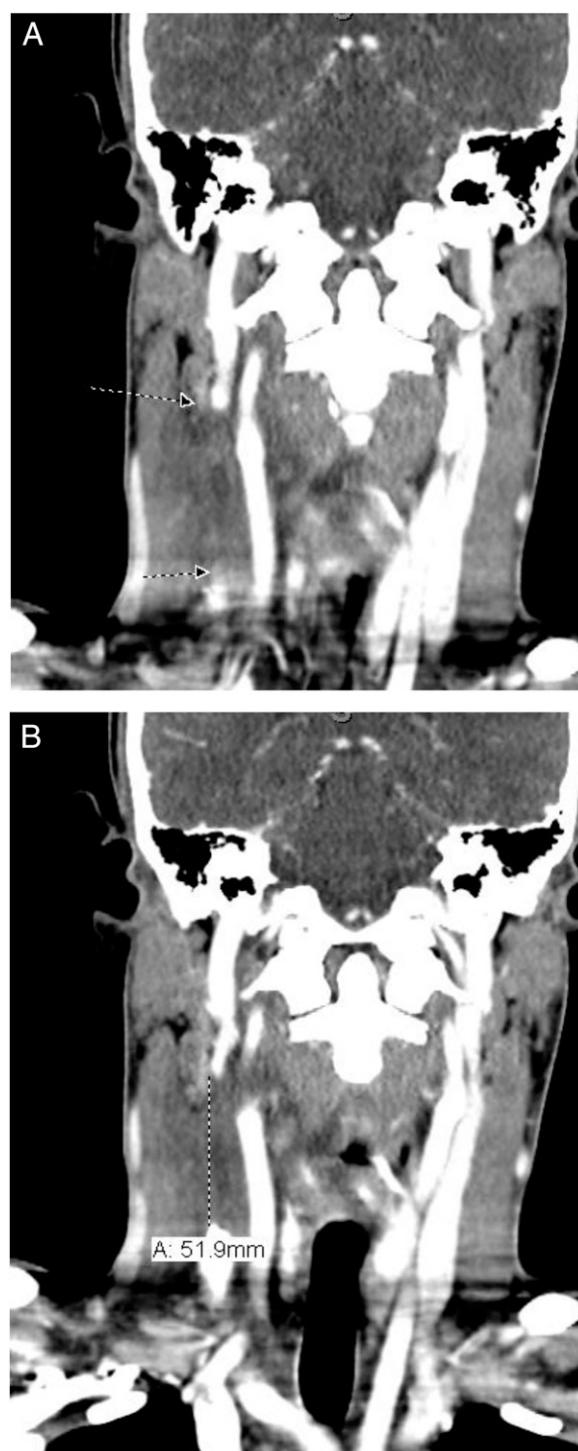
A. Reconstructed coronal computed tomographic scan of the neck with contrast demonstrates an intraluminal filling defect in the right internal jugular vein (arrows). B. The length of occlusion in the internal jugular vein was measured to be 51.9 mm. This filling defect is compatible with thrombus formation.
